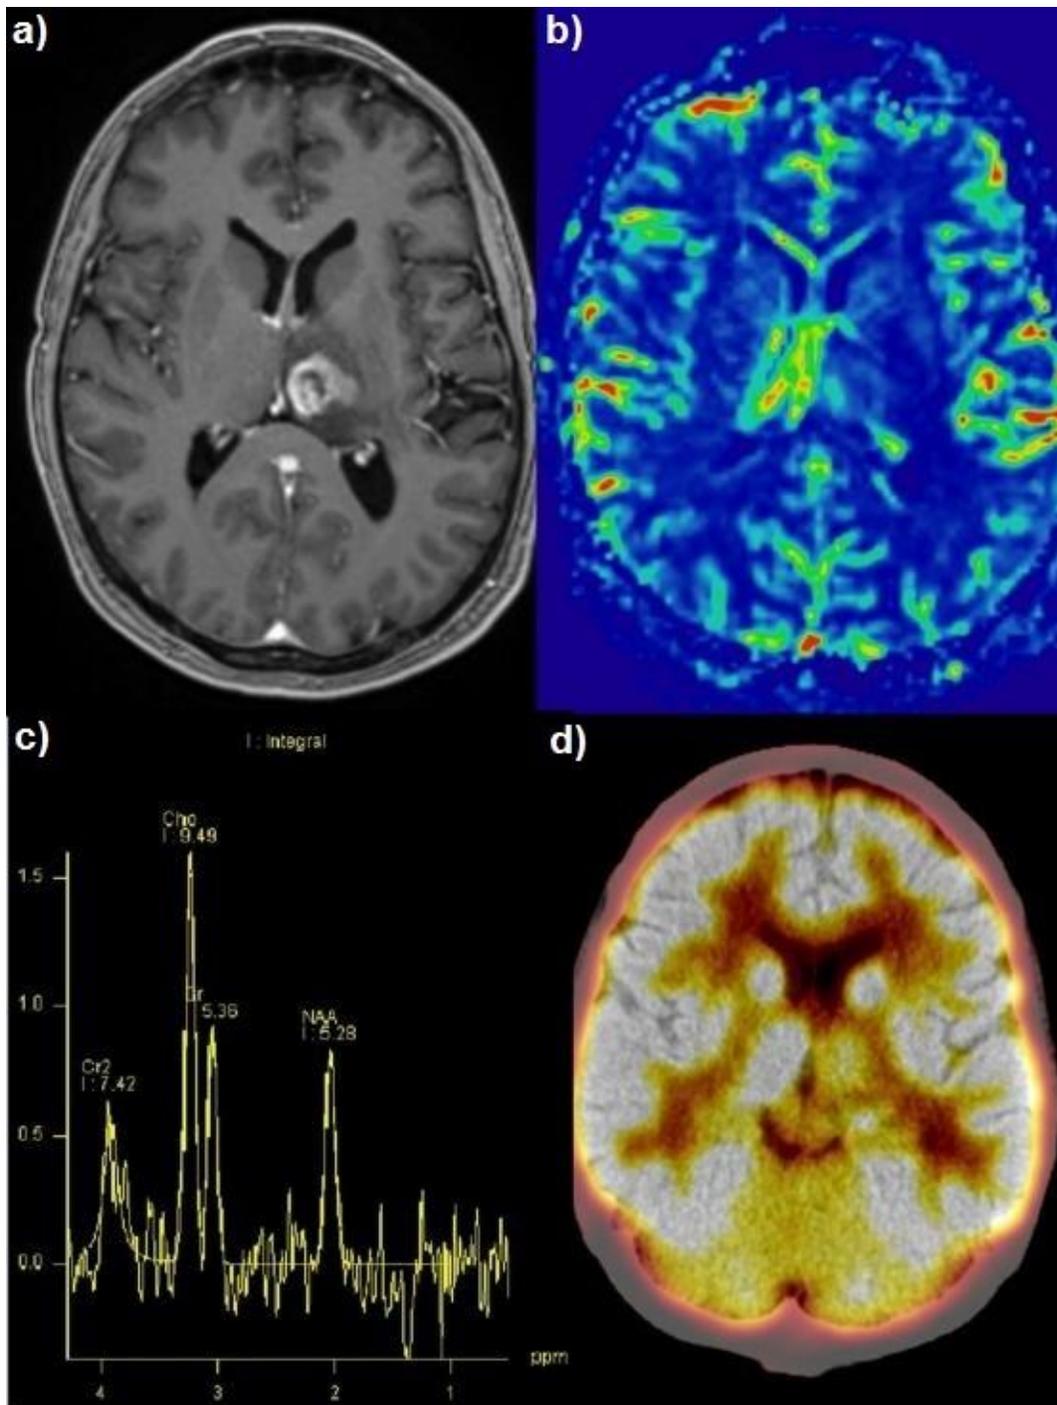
a) Enhancing lesion is seen within the left thalamus, concerning for recurrent glioblastoma. b) The lesion demonstrates decreased cerebral blood volume compared to the contralateral unaffected thalamus. c) The lesion demonstrates elevated Choline-NAA ratio, which can be seen in early radiation necrosis. d) The lesion demonstrates decreased FDG uptake on PET/CT. Overall, findings are consistent with treatment related effects.
